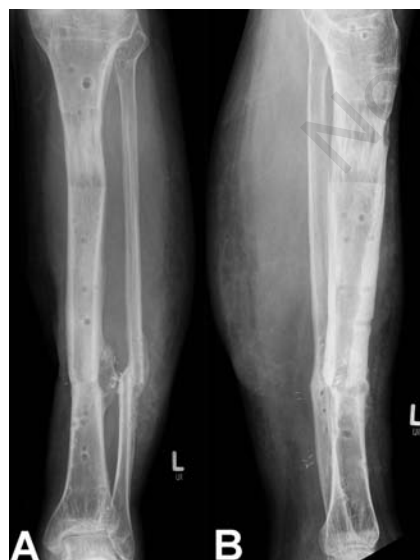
X-rays of Patient 7 four months after frame removal with bony consolidation both of the regenerate and the distal docking site.
